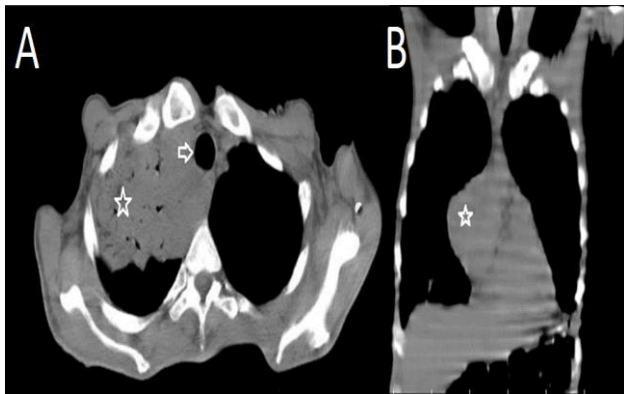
Chest CT mediastinal window-(A) Axial section, evidence of a tumor involving the right pulmonary apex with extension to the mediastinum (star), intimate contact with the airway, but without its obstruction with patent trachea (arrow). (B) Coronal section, which shows mediastinal involvement for the right heart.
